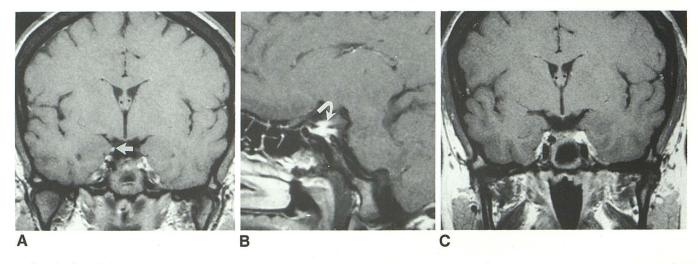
Case 8; 24-year-old woman with unilateral headache and third cranial nerve palsy. Coronal (A) and parasagittal (B) contrastenhanced T1-weighted (600/20) images demonstrate enhancement of the right third cranial nerve (*arrows*). Follow-up study, coronal (C) 1 month later after steroid treatment demonstrates resolution of the third cranial nerve enhancement. The symptoms resolved. Clinical diagnosis: Tolosa-Hunt syndrome.
